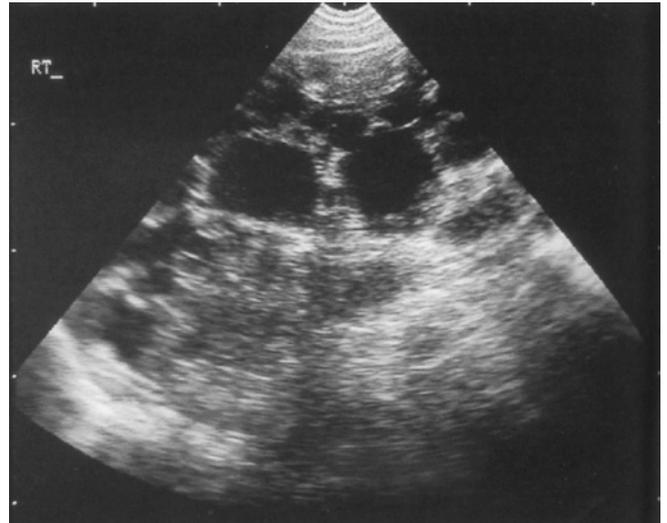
Ultrasound showing polycystic kidney.
